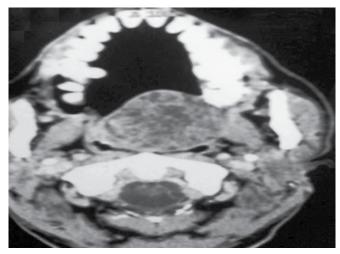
CT scan of neck with coronal section showing mass
